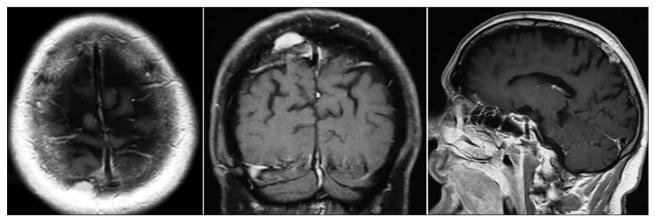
(Left) Axial, (Middle) Coronal, (Right) Sagittal T1-weighted MR images after Gd contrast administration. The mass enhances homogenously in the right parietal bone.
